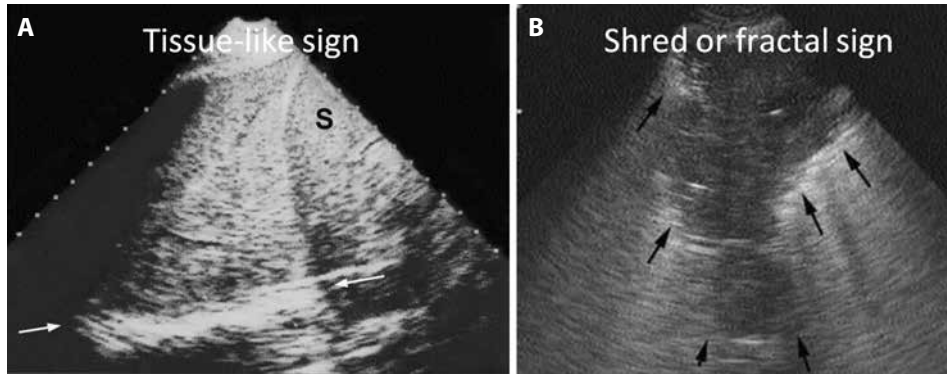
Lung consolidation: shred, fractal and tissue-like sign; A — a massive consolidation (probe at the PLAPS point) of the whole left lower lobe. No aerated lung tissue is present, and no fractal sign can be generated. The lower border is at the level of the mediastinal line (arrows). The pattern is tissue-like, similar to the spleen (S). The thickness of this image is roughly 10 cm, a value incompatible with a pleural effusion. Quantitative data: the 10-cm depth would correspond to a volume of roughly 1 L; B — partial right middle lobe consolidation. This generates a shredded, fractal boundary between the consolidation and the underlying aerated lung (arrows). This is the quite specific shred (or fractal) sign as opposed to the regular lung line in a case of pleural effusion. This anterior consolidation generates the C-profile in the BLUE protocol. Quantitative data: the thickness at the right image is 5.5 cm, corresponding to a 165-mL consolidation, roughly. Adapted from 'Lung ultrasound in the critically ill' [11]
